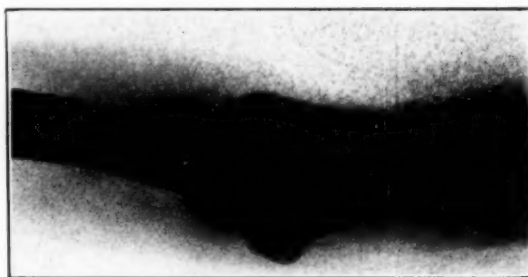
Roentgenograph of upper extremity showing precocious "ripening" of the epiphyses.
